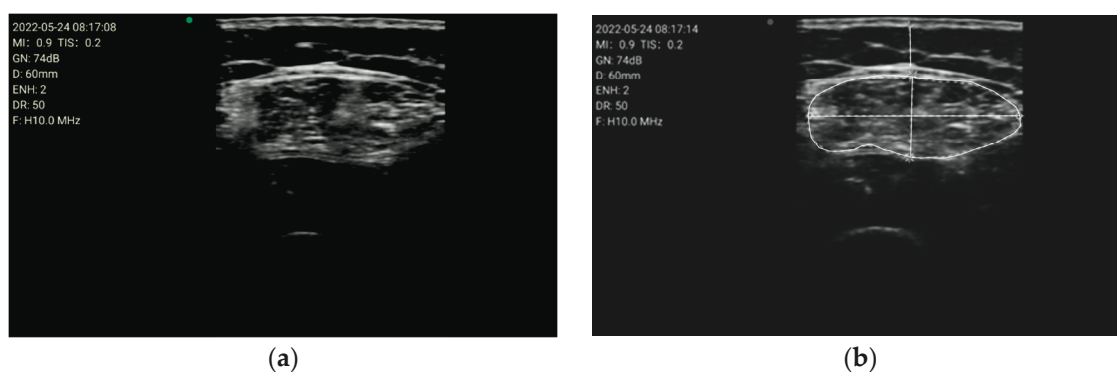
(a) Acquired raw ultrasound image of the unilateral (right) quadriceps rectus femoris muscle in the transverse plane measure by rater 1 (i.e., method A); (b) Measurement of the variables by the conventional method using the ultrasound imaging device tools, by rater 1 (i.e., method A), for the parameters of the cross-sectional area, the Y-axis, i.e., transverse muscle thickness (MT), and the subcutaneous fat thickness (SFT).
